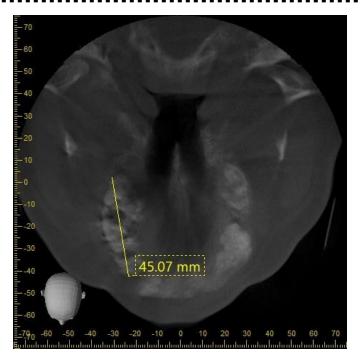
CBCT Axial View
